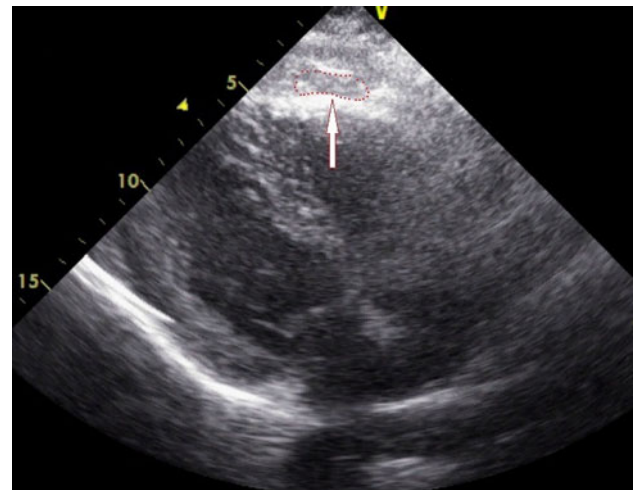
Epicardial fat thickness. Echocardiographic parasternal long-axis views of epicardial fat thickness (the echo free space within the red dotted line)
